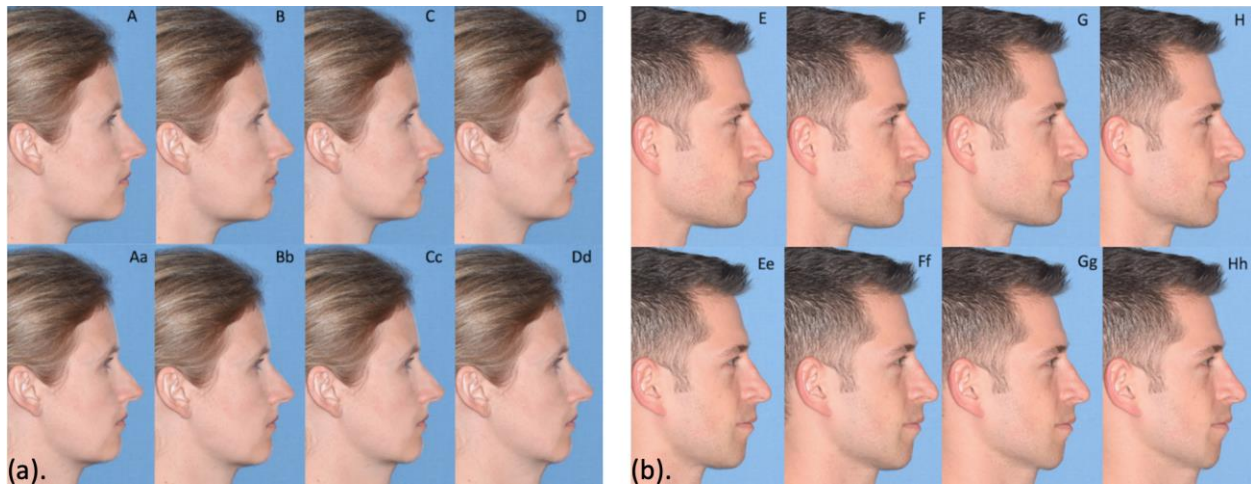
All images were calibrated using superimpositions of the patient's original lateral cephalometric radiographs with digital 100mm rulers and gridline measurements to adjust for any resizing and magnification errors. This process ensured the digital measurements would represent clinically applicable C-T lengths. Because the images had already had the facial convexities altered, the original lateral cephalometric radiographs would not adapt fully in the lower third.
